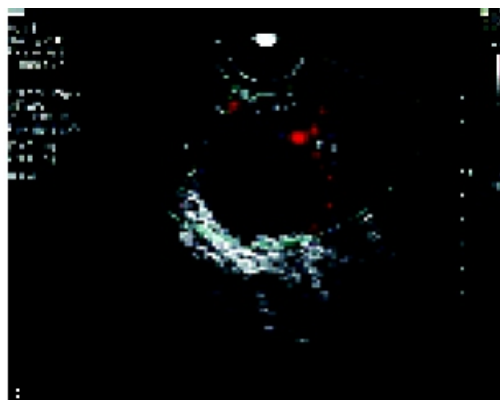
Less than 25% blood flow around follicle as seen by Doppler
